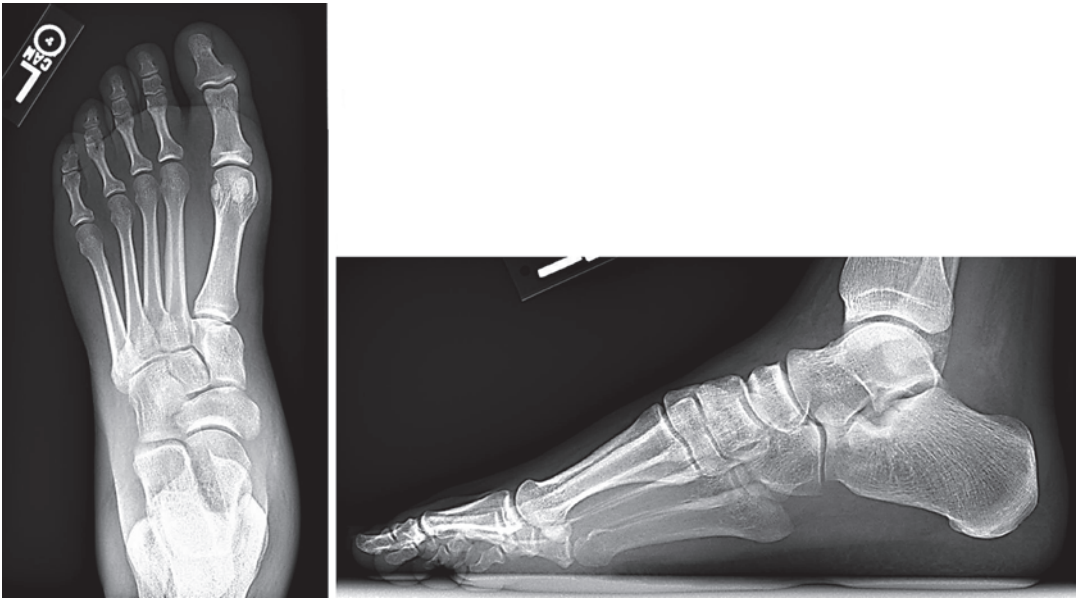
Sustentacular fractures can be subtle and easily missed on plain radiography. AP and lateral foot X-rays demonstrate an isolated sustentaculum tali fracture
